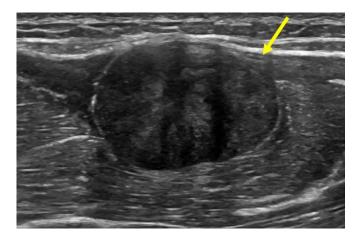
Long-axis superficial ultrasound image of the left upper arm shows a soft tissue mass (yellow arrow).
